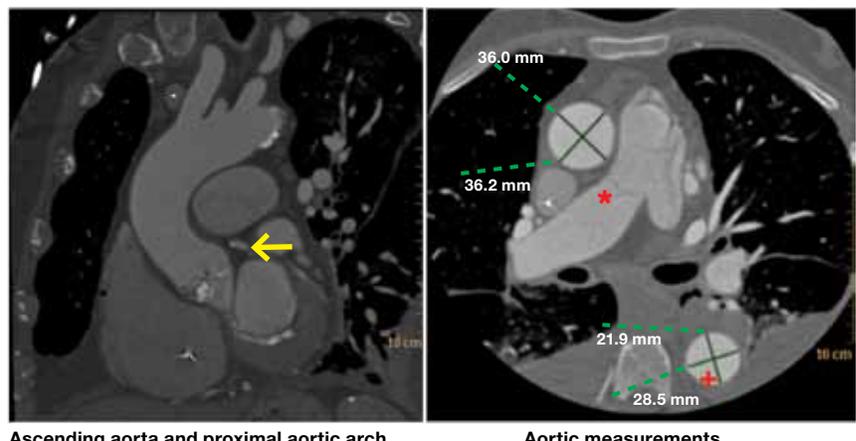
Assessment of the aortic arch and great vessels by CTA.
